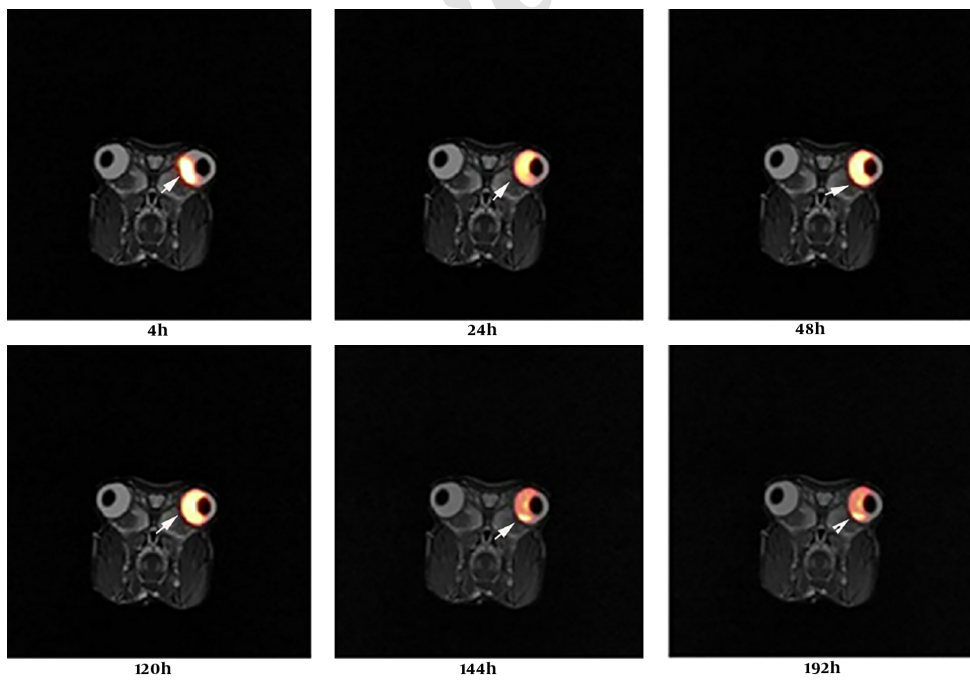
Fused positron emission tomography/magnetic resonance imaging (PET/MRI) images obtained via static imaging after ^{89}Zr -bevacizumab injection
